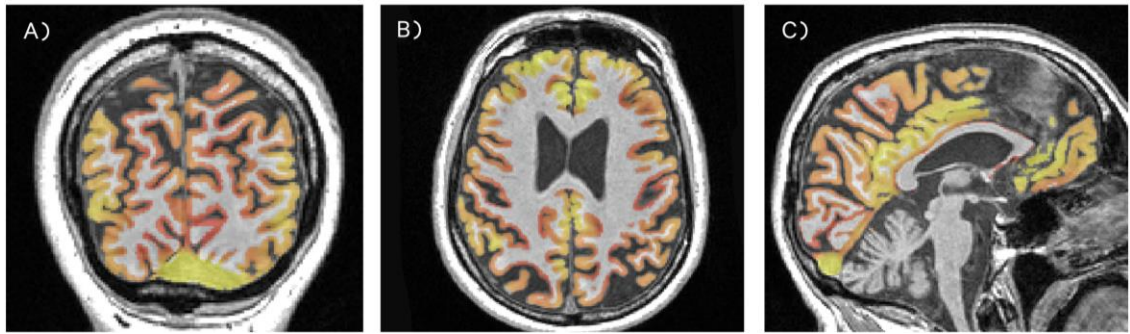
An example of an ANTs CT segmentation for a participant showing disease related atrophy shown in (A) coronal, (B) axial and (C) sagittal views. Spillage of the CT segmentation into the occipital dura is particularly pronounced in the coronal and sagittal views.
